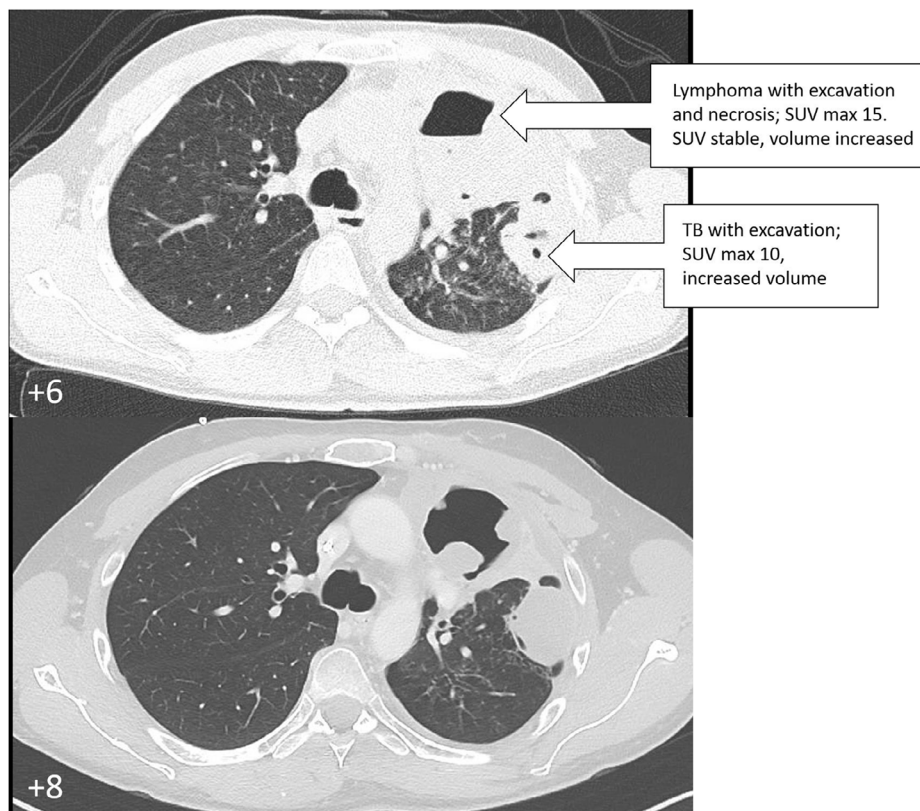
Upper panel: CT scan, performed after nearly 11 weeks of antitubercular therapy: a radiological progression of lymphoma and TB lesions is shown, with the appearance of excavations. CAR T-cell therapy was administered 2 weeks later. Lower panel: 1 month after CAR-T the CT scan showed an evolution in the radiological findings: the lesion where the lymphoma used to be increased in volume, mainly excavated component, which could be an effect of CAR T-cell therapy. The TB lesion became more consolidated.
